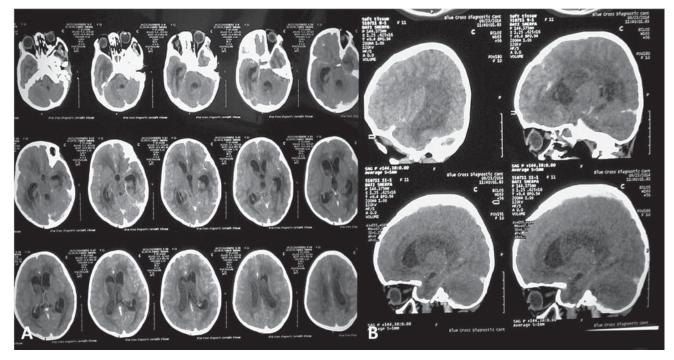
CT scan of brain A) Axial B) Sagittal, with contrast showing isodense mass in bilateral lateral ventricles more on posterior horns, i.e. in dependent part sparing frontal horns suggesting liquid i.e. abscess
